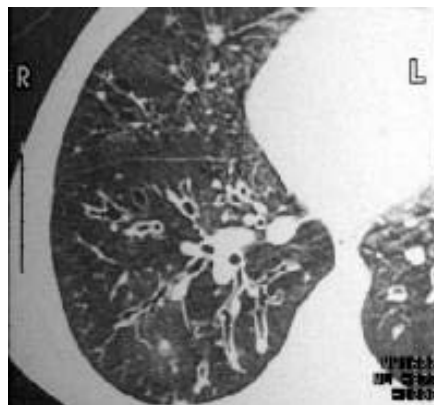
CT scan shows varicose bronchiectasis with alternating areas of bronchial dilatation and constriction (*Tsang et al., 2005*).
